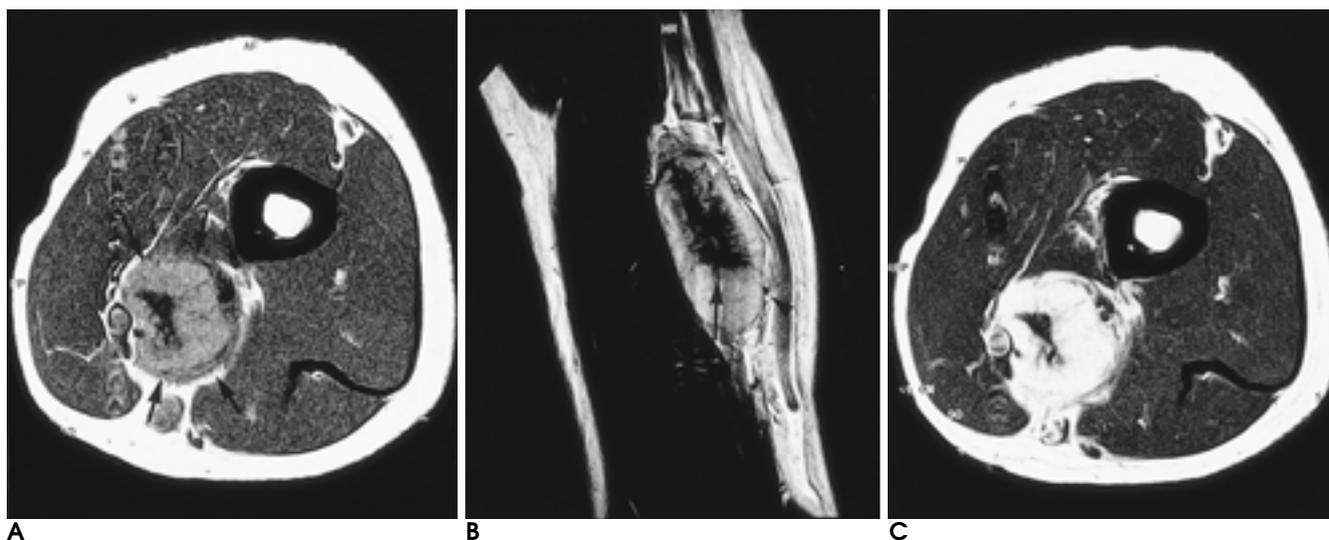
A. Axial T1-weighted image shows a relatively well-defined mass (arrows) of slight hyperintensity compared with adjacent muscles in the upper arm which is seen near neurovascular bundles and between the muscles.
